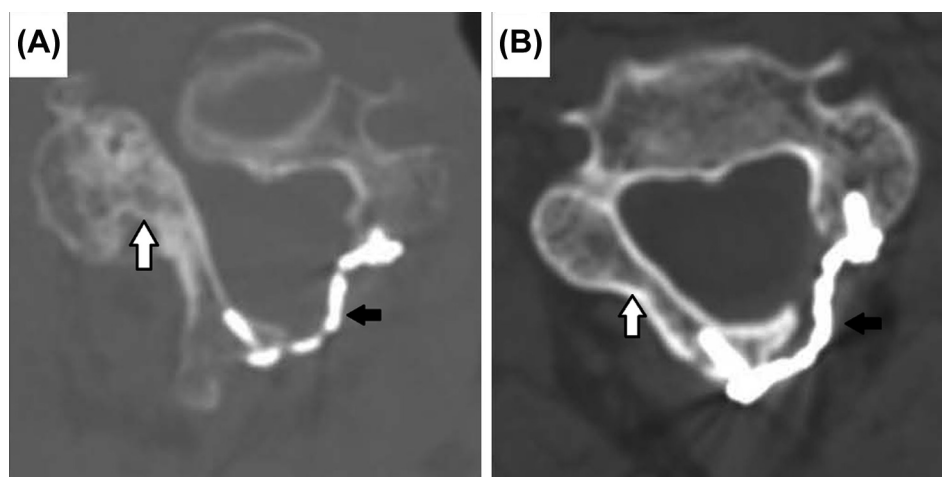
Axial computed tomography scans of (A) conventional and (B) modified expansive open-door laminoplasty at 6 months postoperatively. Both pictures reveal hinge-side good union and well-positioned titanium miniplates and screws without any loosening (black arrow). More medial gutter (white arrow) is noted in the picture of modified techniques.
